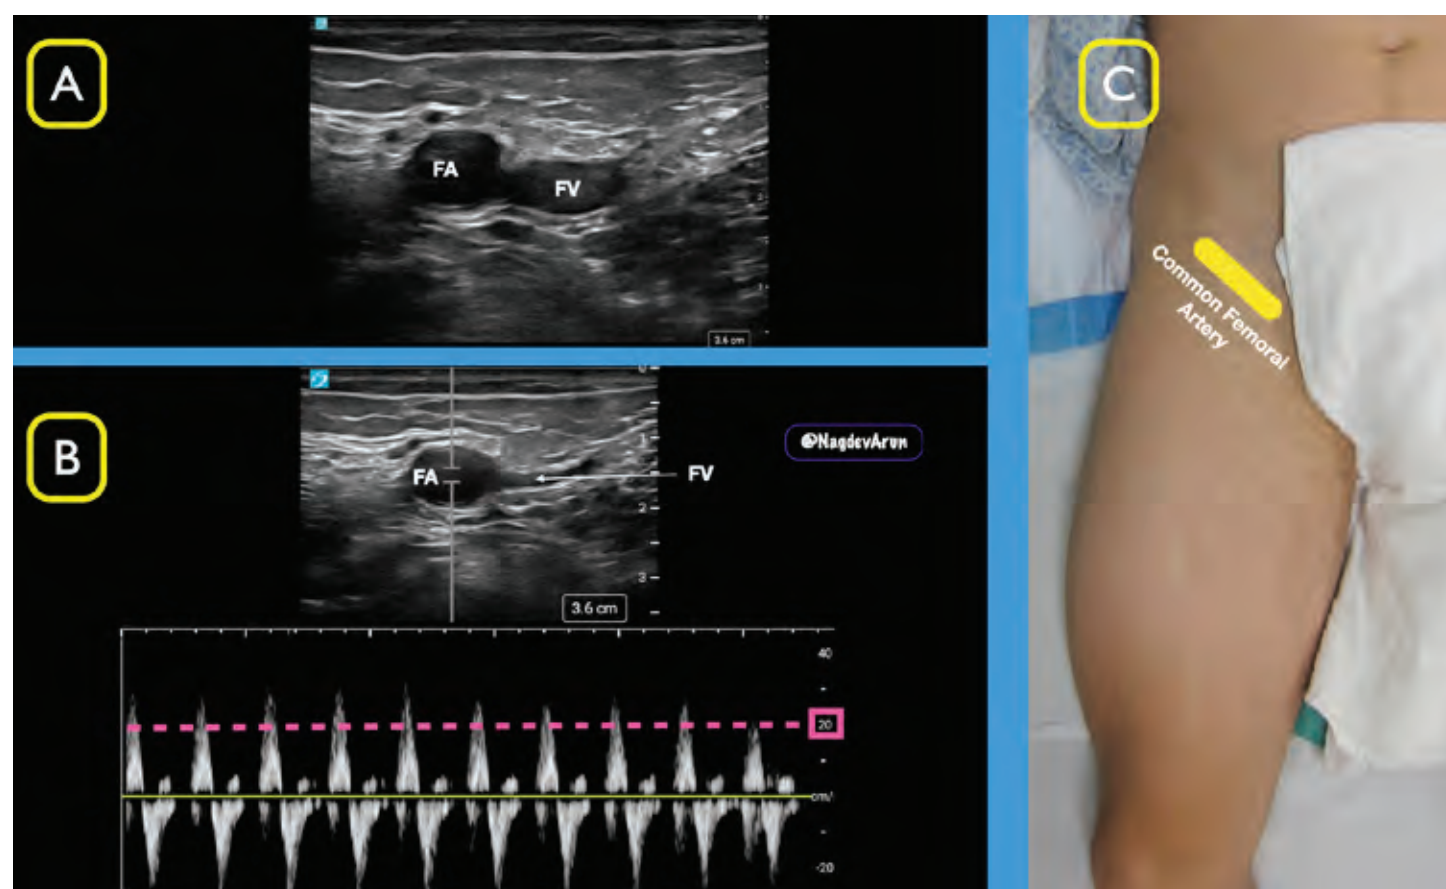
A) Compress the common femoral vein (FV) and visualize pulses in the common femoral artery (FA) B) Using spectral doppler, define a peak systolic velocity (PSV) >20 cm/sec C) Using a linear probe in the inguinal crease, locate the common femoral artery and vein
